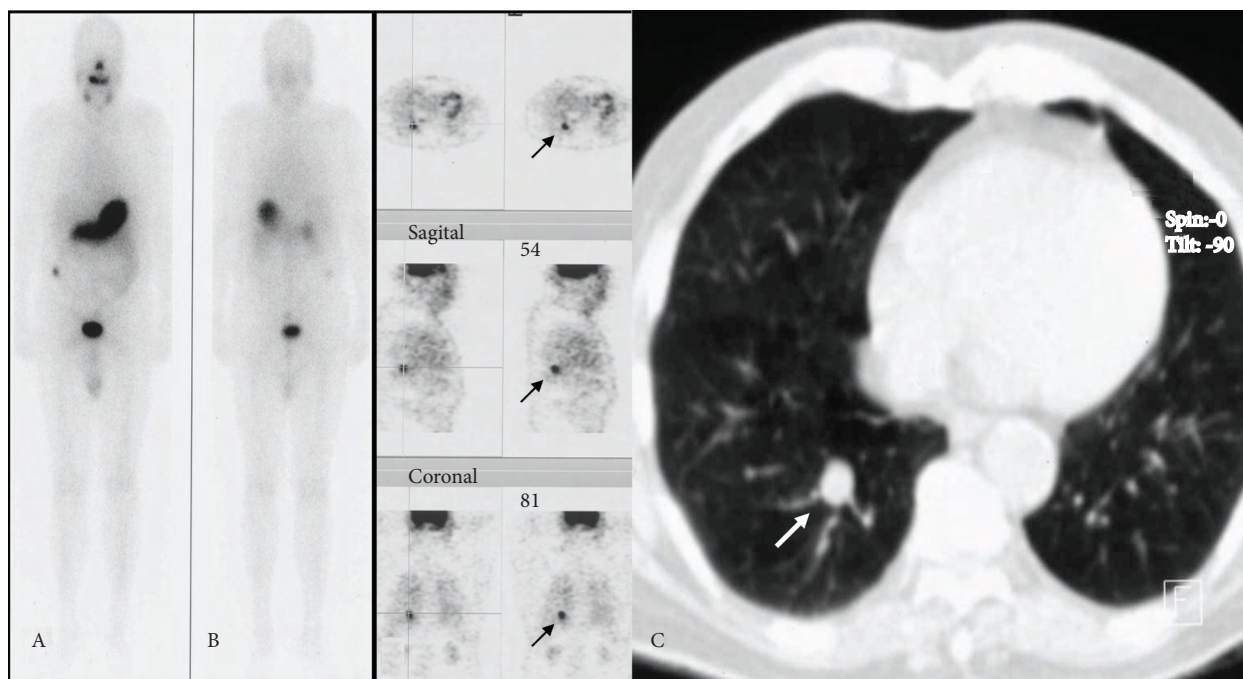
A 79-year-old male with papillary thyroid carcinoma presented with elevated serum Tg. He had undergone thyroid surgery and radioablation 6 years earlier and received a second radioiodine treatment of 250 mCi of I-131. Post-treatment whole-body scanning was negative (A); however, a metastatic lesion in the right lower lung was seen on FDG-PET images (B, arrow) and CT (C, white arrow). The patient also had cervical lymph node involvement (not shown) and was prepared for cervical dissection; however, surgical intervention was canceled because a lung metastasis was observed with PET.
